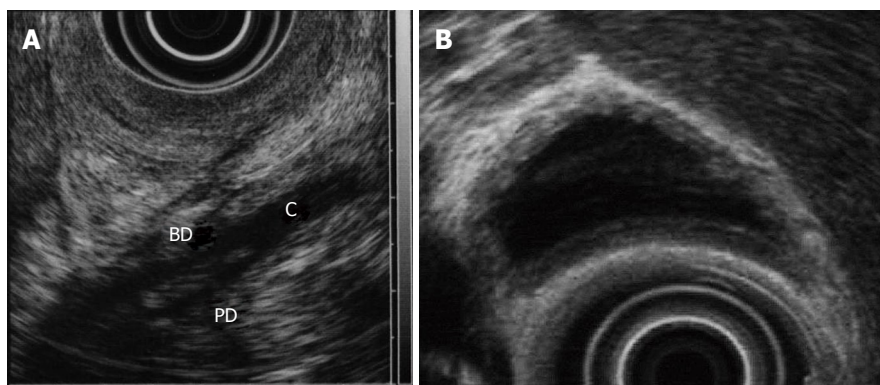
Endoscopic ultrasonography of a pancreaticobiliary maljunction patient. A: The confluence of pancreatic duct and bile duct in the proximal portion of the duodenal wall; B: thickness of inner low echoic layer of the gallbladder. BD: bile duct; PD: pancreatic duct; C: common channel.
